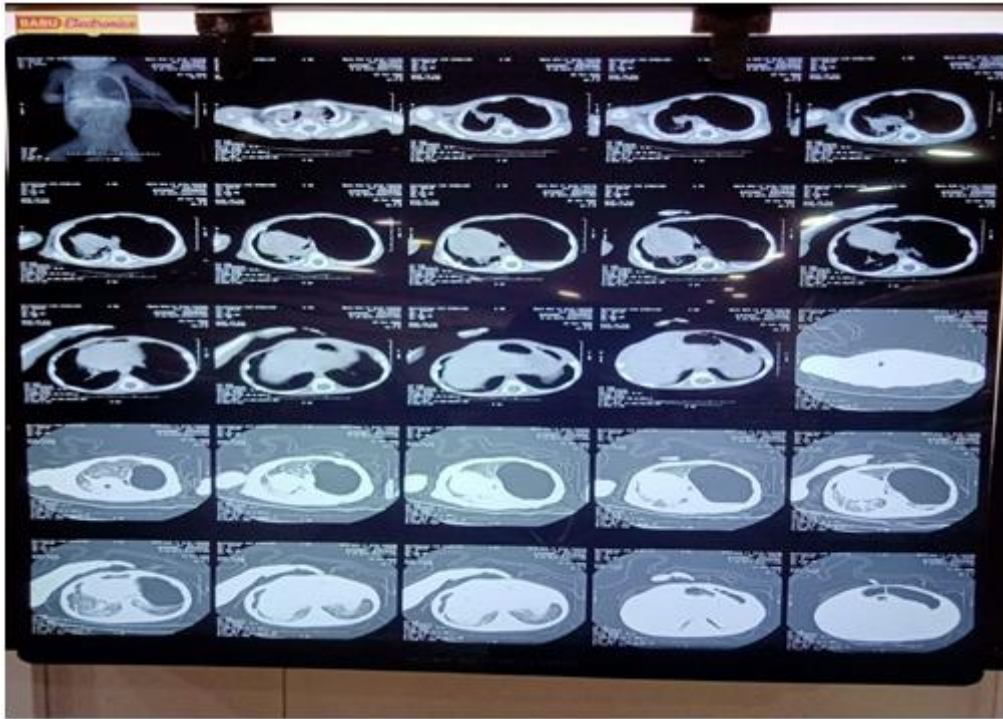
HRCT shows L lower lobe CLO with mediastinal shift to R side
